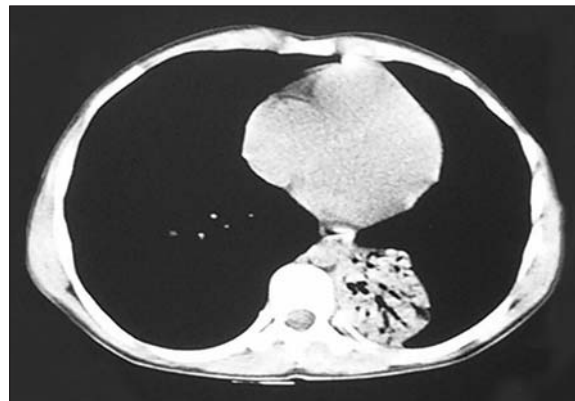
Computed tomography of the lung showing left lower lobe atelectasis and consolidation.
